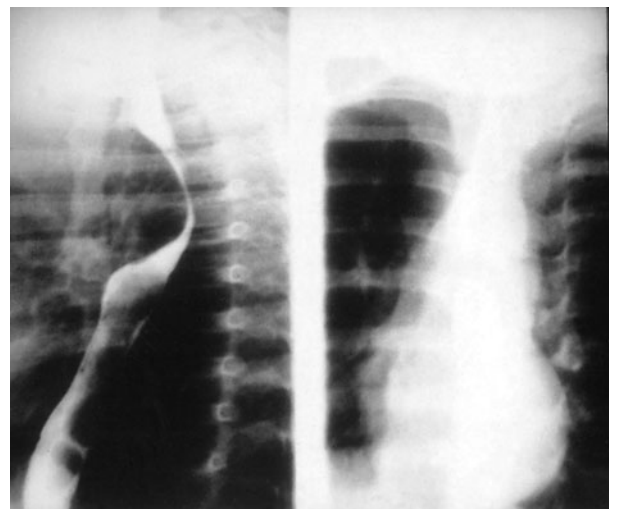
Bronchogenic cyst showing displacement of esophagus. Normal appearing chest x-ray.
